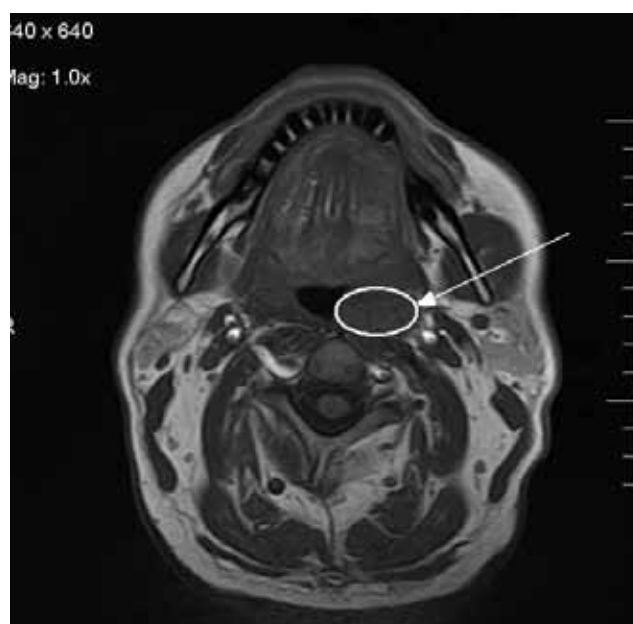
MRI scan of the head. Haematoma at the tongue base, located on the posterior wall of the nasopharynx on the left (arrow)
